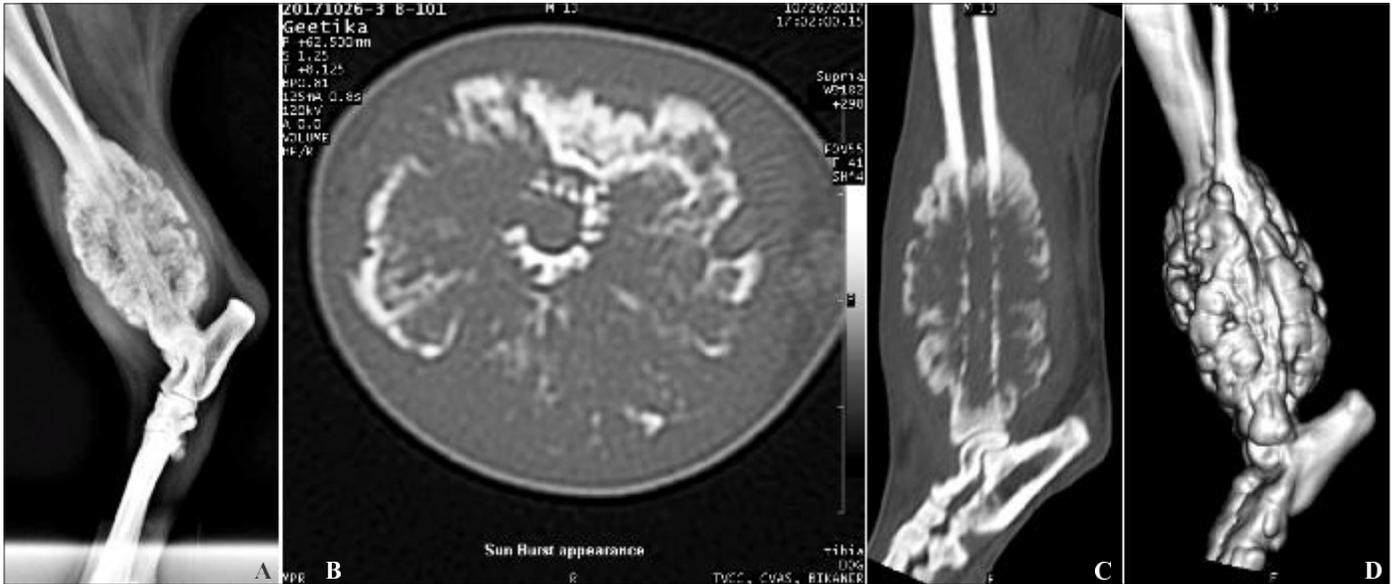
Radiographic image (A) Showing mottled, irregular lysis of cortical bone with 'amorphous' periosteal reaction. Axial CT image (B) showing 'sunburst' appearance and osteolytic and proliferative changes. Sagittal plane (C) and 3D (D) reconstructed image showing mixed pattern osteolysis; reduced radiopacity of bone compared with soft tissues (ghostly bones).
